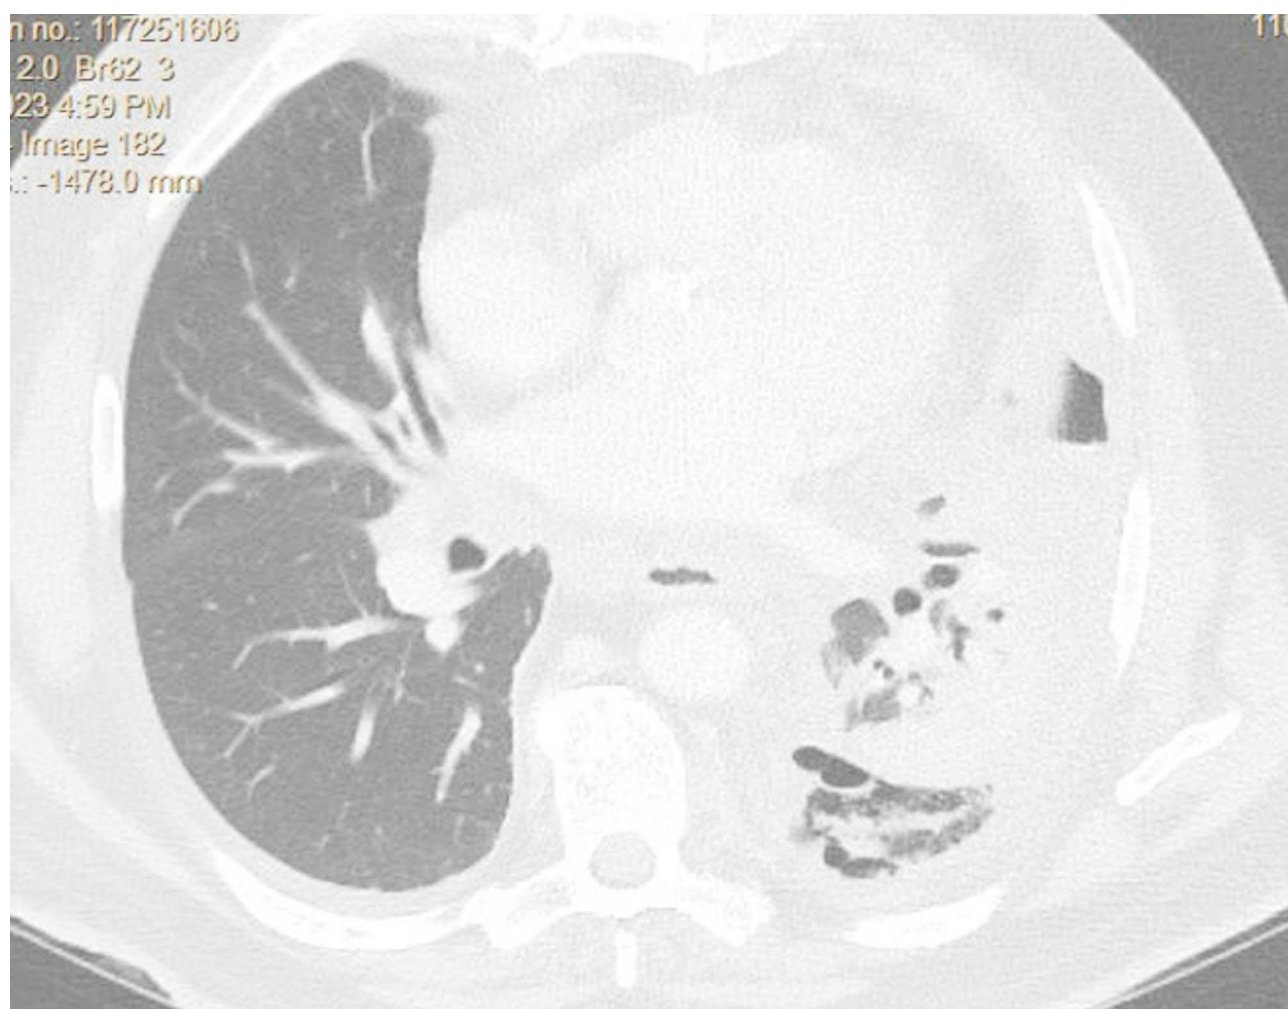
Computed tomography of the chest showing left multilocular effusions with pericardiac mediastinal mass corresponding to biopsy proven lymphangioma
